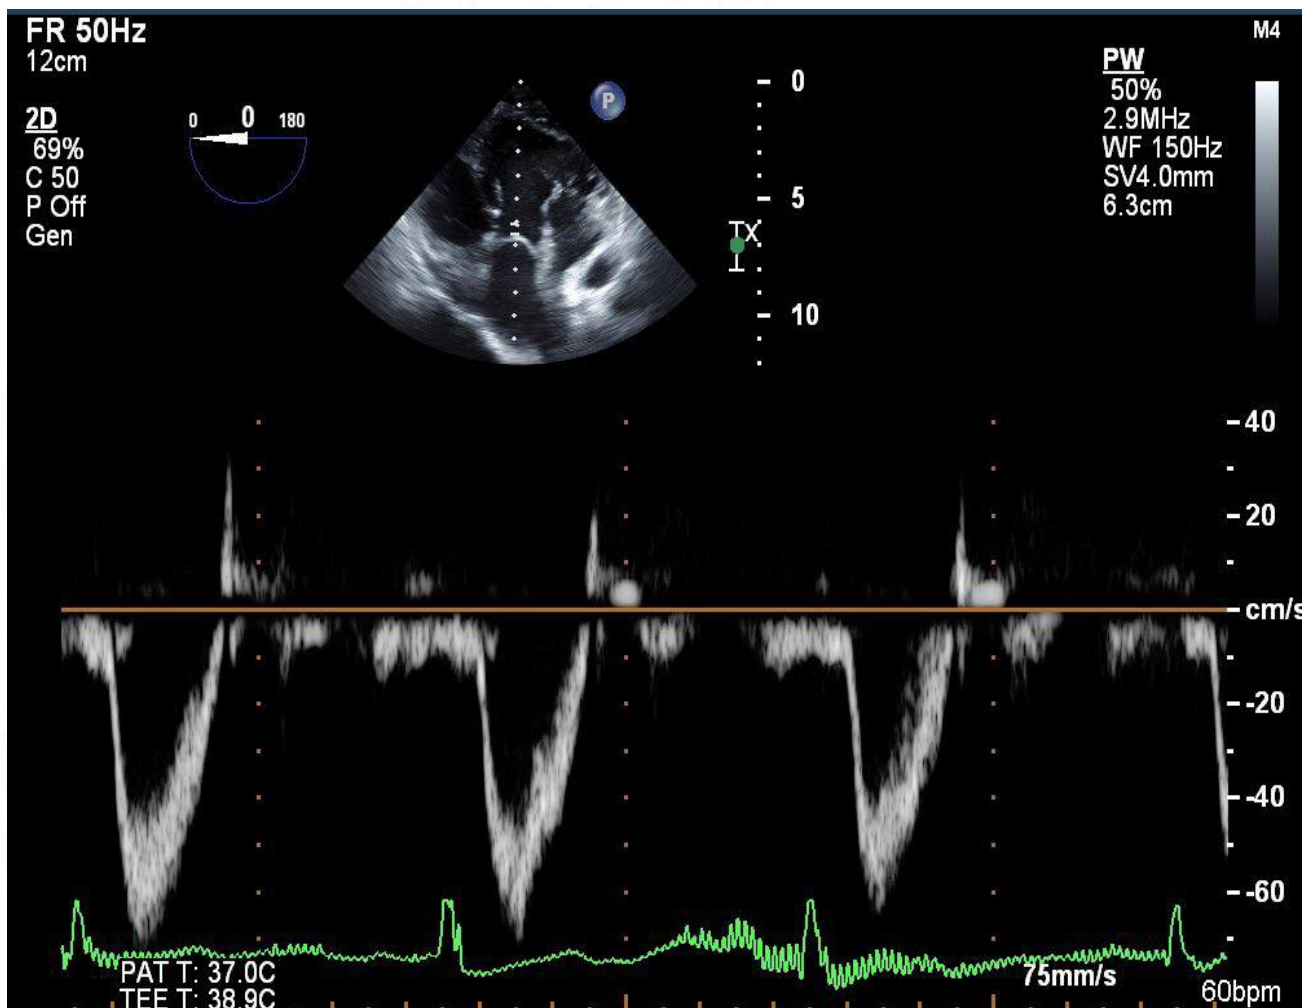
TEE Deep transgastric LVOT view with pulse-wave doppler measurement for calculating LVOT VTI.
